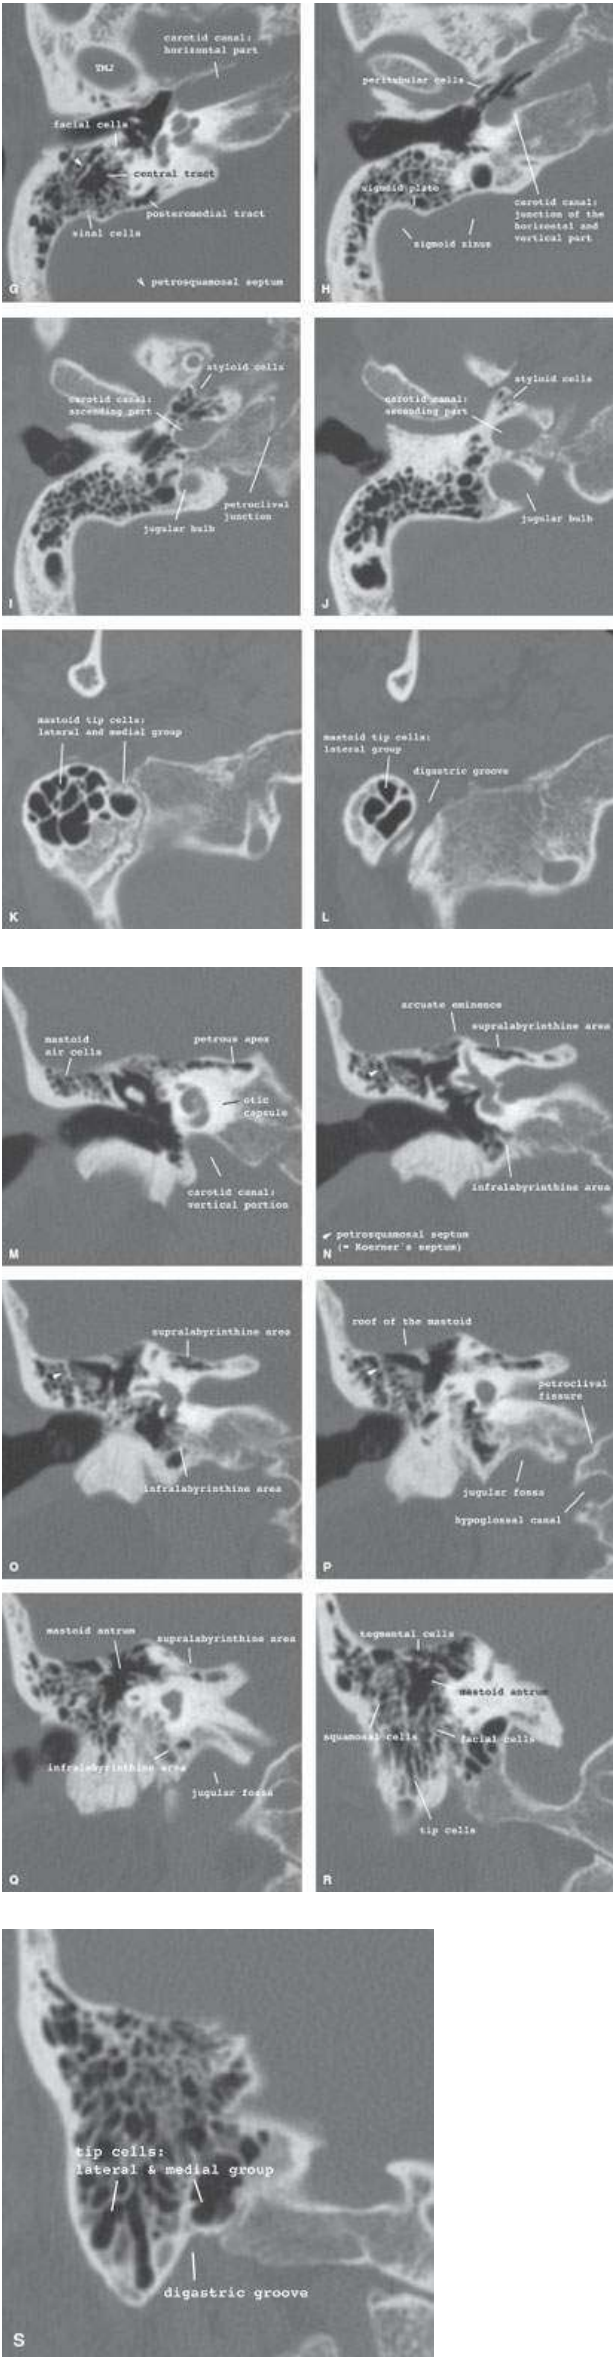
Normal anatomy of the mastoid pneumatization on axial (A–G) and coronal (M–S) CT Sections. Several pneumatization tracts extend from the central mastoid antrum.
